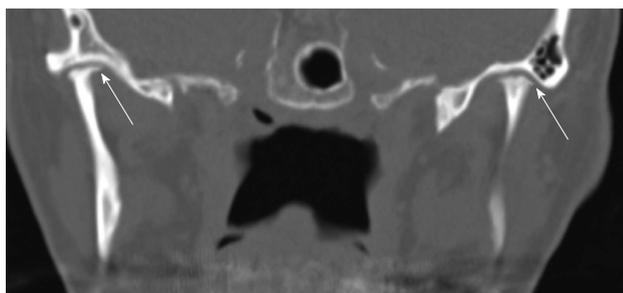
Idiopathic condylar resorption. Coronal reformatted computed tomography image through the temporomandibular joint of a young patient demonstrates bilateral severe condylar resorption (arrows) without any evidence of degenerative changes within the joint.
